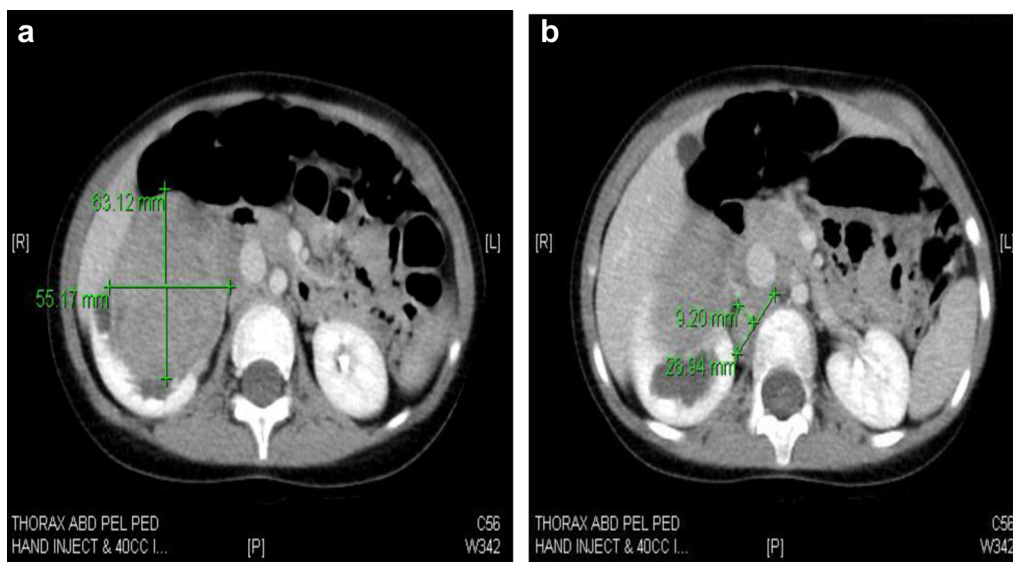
(a): CT image showing a large, retroperitoneal solid mass (6.3 cm \times 5.5 cm) occupying most of the right kidney. The dimensions of the mass are highlighted by the green lines. Note is also made of hydronephrosis of the upper pole. (b) Another CT image showing a smaller extra renal nodule of soft tissue with punctate calcifications lying adjacent to the right adrenal gland measuring 2.7 cm \times 0.9 cm (the dimensions of the mass are highlighted with green lines).
